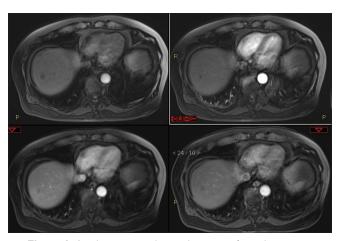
Axial contrast-enhanced images of initial magnetic resonance imaging liver
